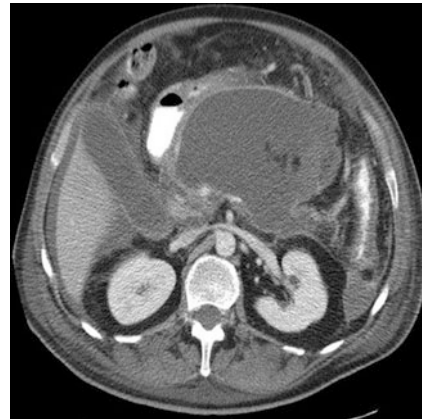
CT scan of walled-off pancreatic necrosis 5 weeks after onset of acute necrotizing pancreatitis. A large collection replacing the pancreas is seen
